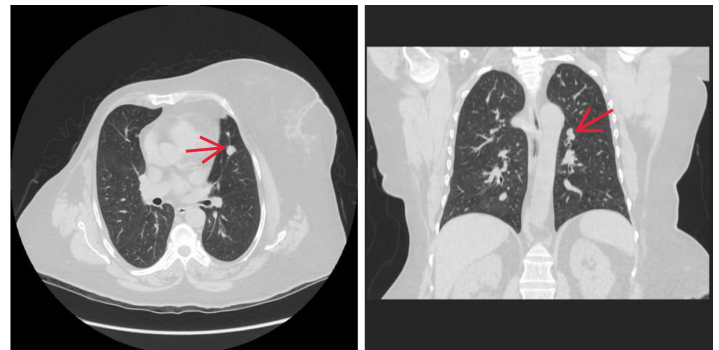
Image of CT scan showing suspicious pulmonary nodules.
